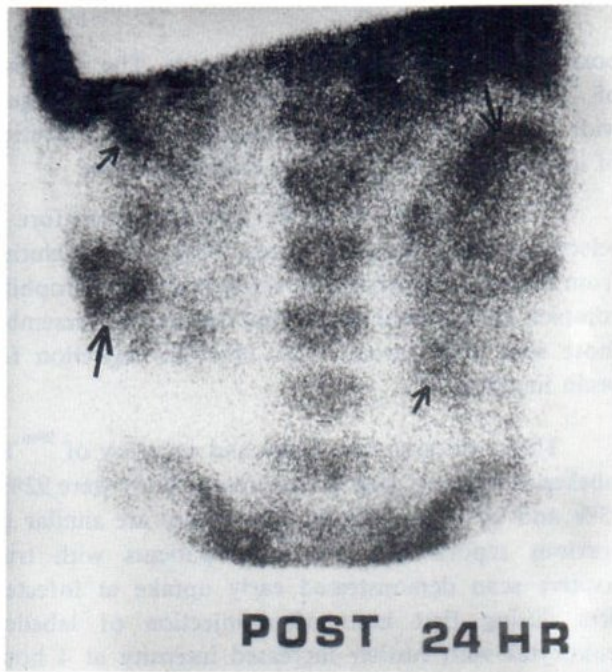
Posterior view of 24 hour image of a patient with polycystic renal disease shows multiple areas of abnormal uptake in both enlarged polycystic kidneys (arrows). Ultrasound and CT scan did not reveal a source of infection.
